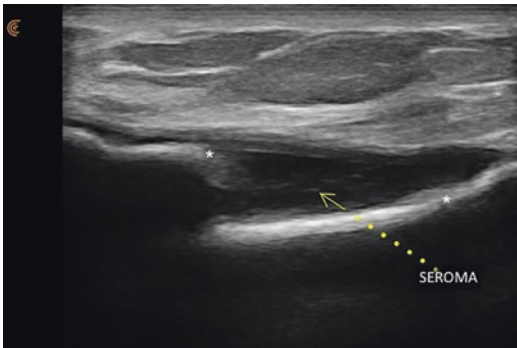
Grayscale ultrasound image of a broken silicone gel breast implant with mostly anechoic fluid between the elastomer shell and the periprosthetic capsule. * denotes the elastomer shell
